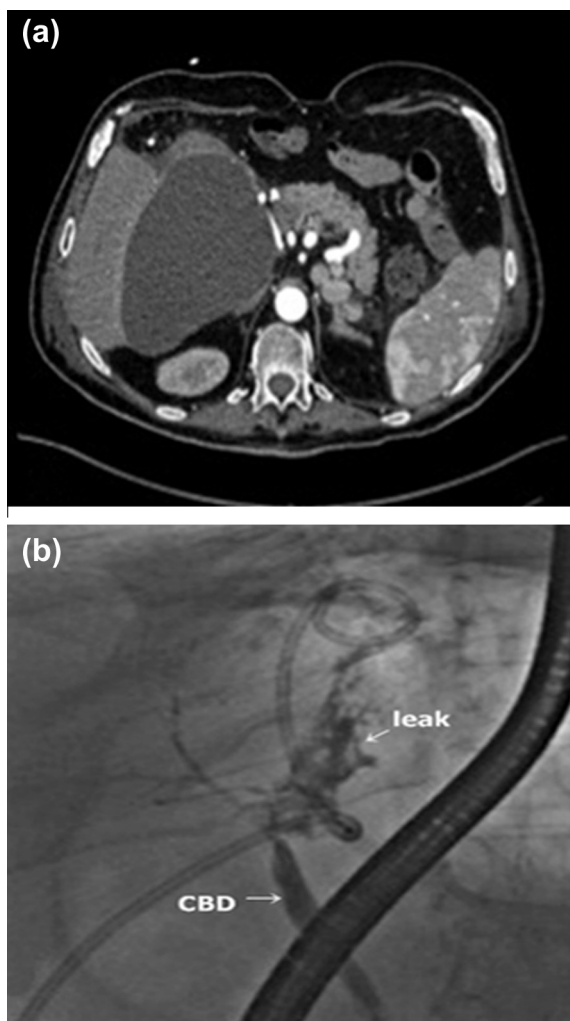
Fifty-seven year old male recipient complaining of jaundice and elevated liver enzymes. (a) Axial CT image showing a large biloma at graft cut surface (b) ERCP image showing anastomotic leakage and minimally dilated intrahepatic bile ducts.
